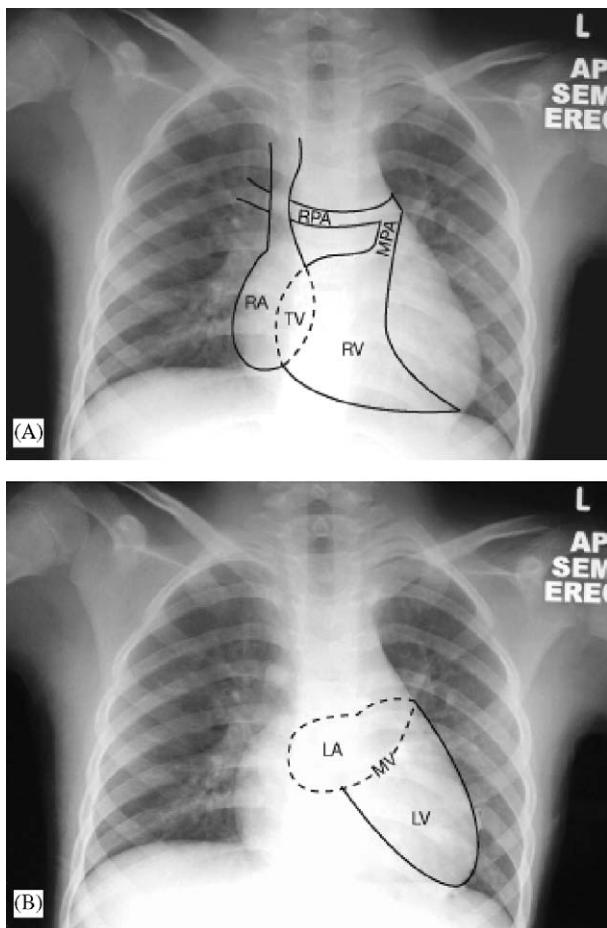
(A) Radiographic position of normal right heart structures. RA, right atrium; TV, tricuspid valve; RV, right ventricle; MPA, main pulmonary artery; LPA left pulmonary artery. (B) Radiographic position of normal left heart structures. LA, left atrium; MV, mitral valve; LV, left ventricle.
